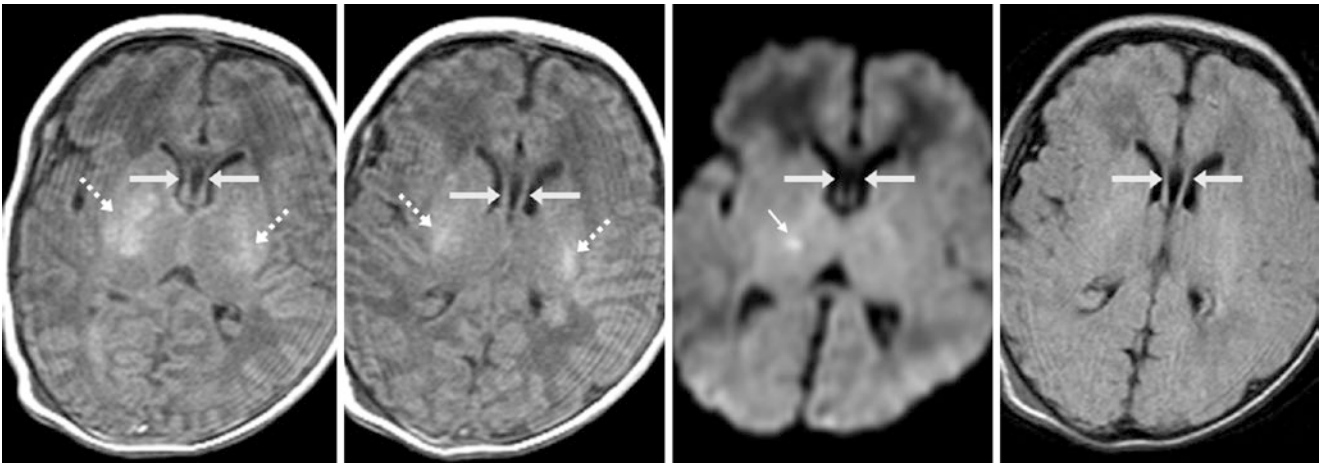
A 2-day-old term infant with severe hypoxic-ischemic injury (HII, *dashed arrows*) on MRI and an incidental, tiny CSP (*arrows*) anteriorly. The HII is represented by bright T1 signal within the posterior putamina on axial T1WI (*dashed arrows, left two images*) and by
